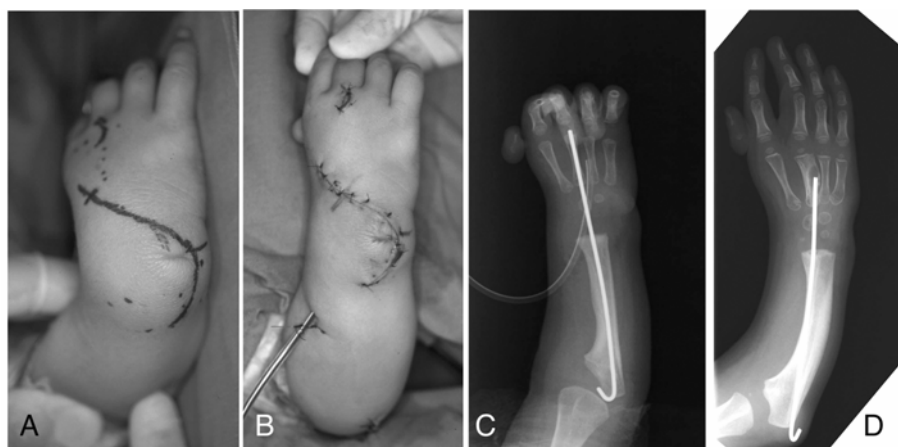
Centralization and postoperative X-ray film. A, B, C, Centralization at the age of 22 months. A, Dorsal S-shaped skin incision. B, Appearance immediately after operation. C, X-ray film immediately after operation. D, X-ray film shows cyst formation, possibly due to mechanical stress caused by the Kirschner wire, at 9 months after centralization (at 31-months-old).
